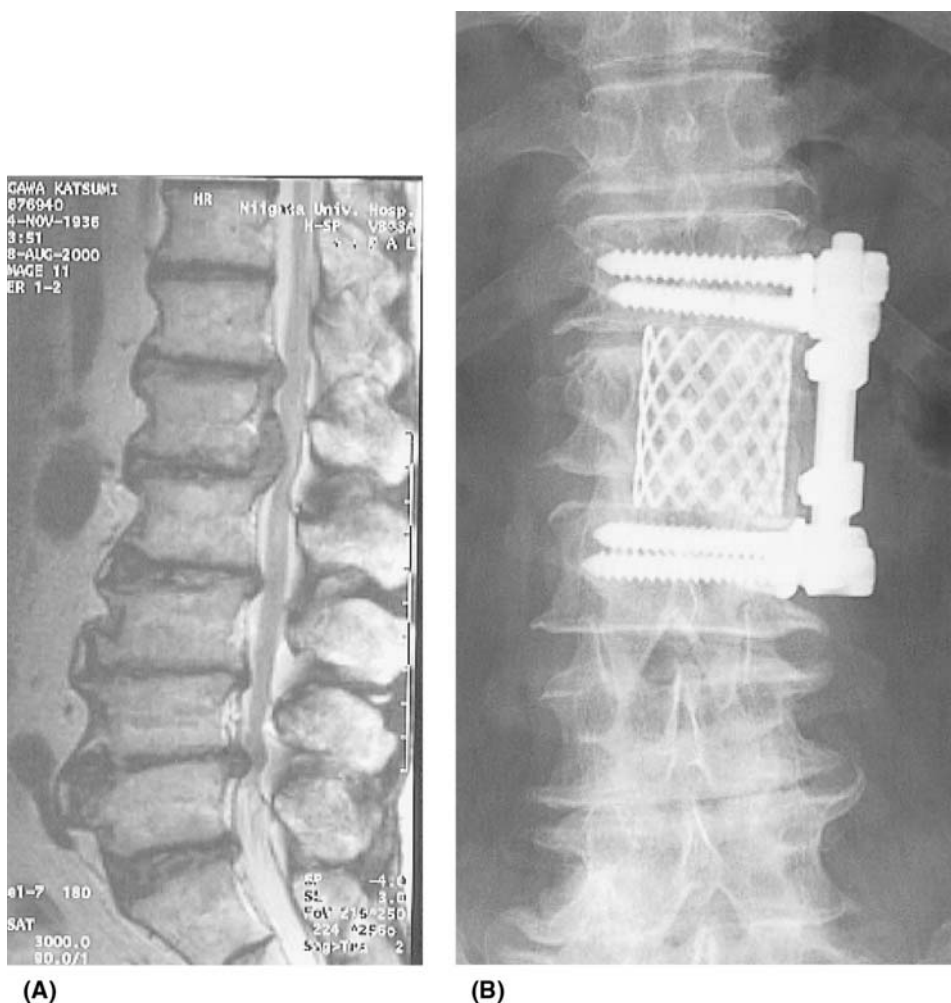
Case 1: a 63-year-old man with T12–L2 stenosis due to hypertrophic posterior longitudinal ligament. (A) Preoperative MRI; (B) radiograph 2 years after surgery.
